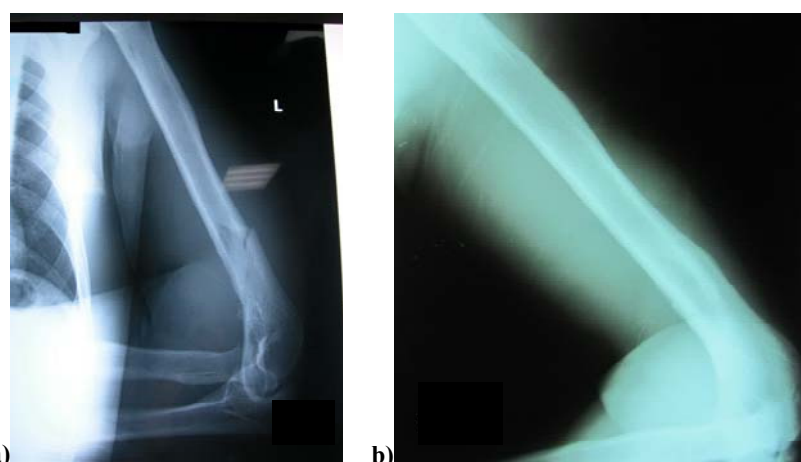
Patient B: a) initial radiography done at the Emergency Room Department on the day of injury; b) radiography done six months after the injury (treatment with a hanging arm cast).
